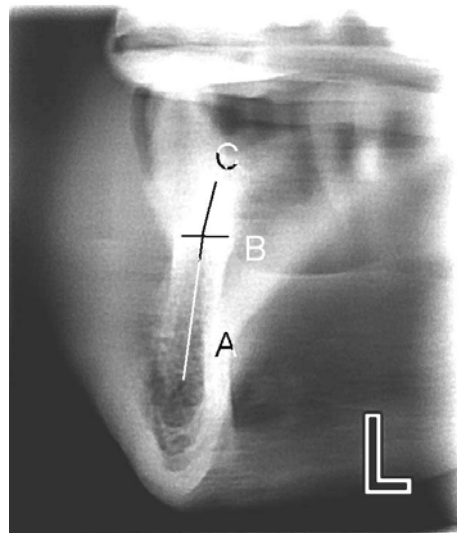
Radiograph three months later
